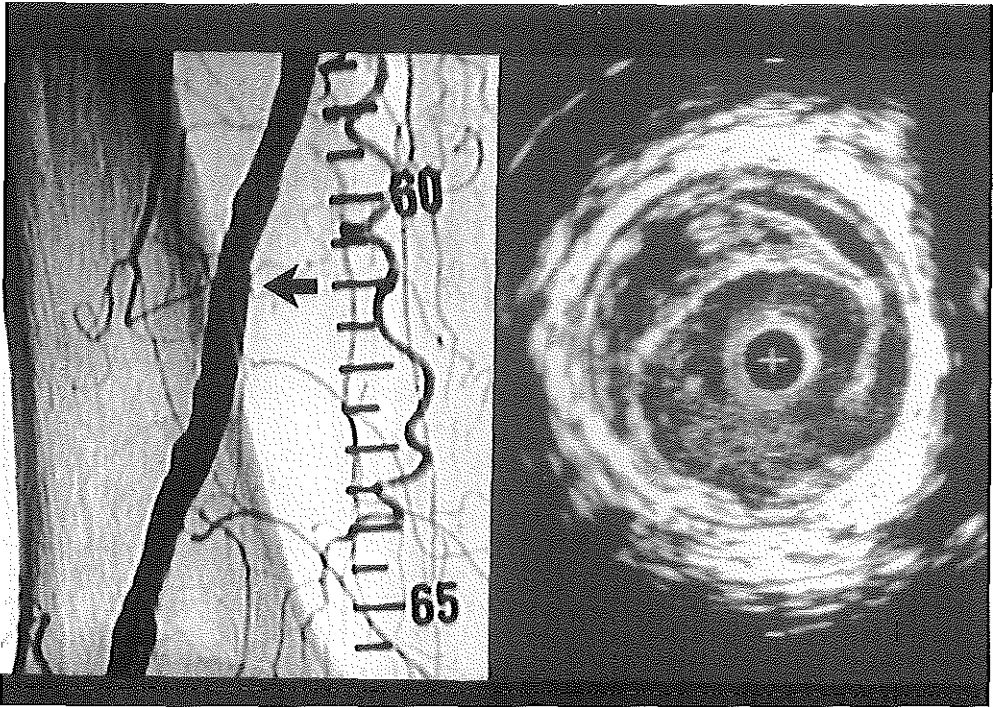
Angiogram and corresponding intravascular ultrasound (IVUS) cross-section of the femoropopliteal artery after balloon angioplasty. Whereas no vascular damage is evidenced angiographically, IVUS detects a dissection of 120° at level 61. The white lines seen between level 60.5 and level 62.0 are caused by a smaller artery projected over the femoropopliteal artery. + = catheter; calibration = 1 mm.
